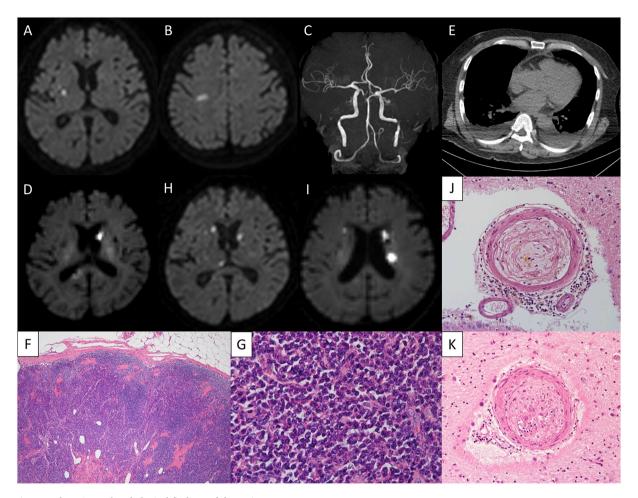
Brain MRI, chest CT, and pathological findings of the patient.
